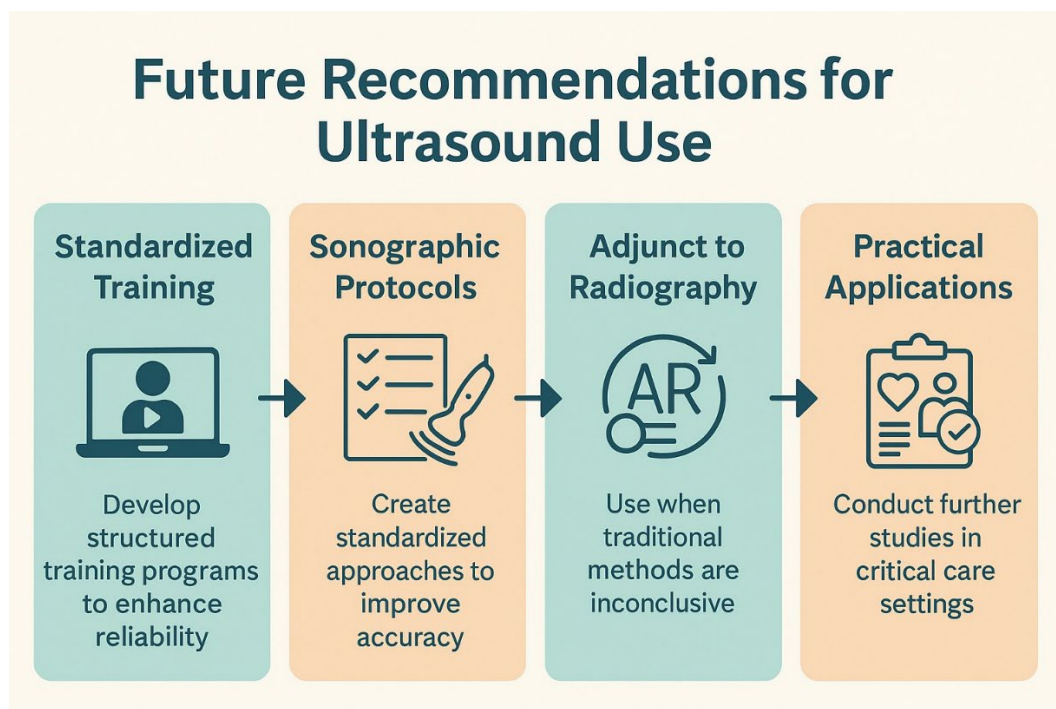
Key recommendations from the literature on ultrasound-guided NGT verification.
